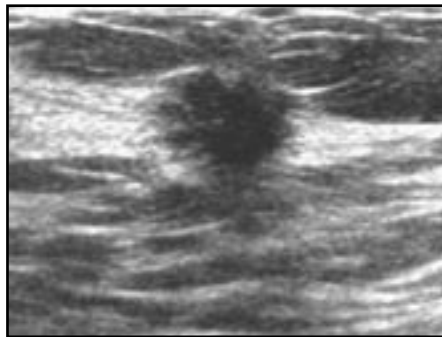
Solid, hypoechoic, irregular lesion interrupting the surrounding architecture – a malignant sonographic appearance
